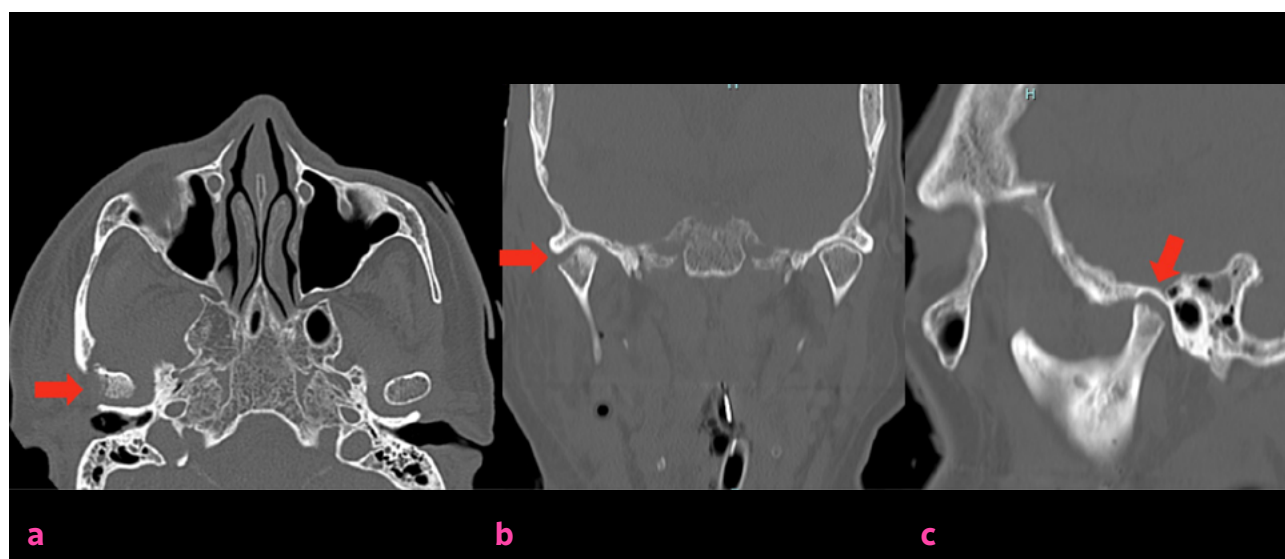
CT scans in axial (a), coronal (b), and sagittal (c) views. Loss of cortical bone and flattening of the lateral pole of the right mandibular condyle are evident.
